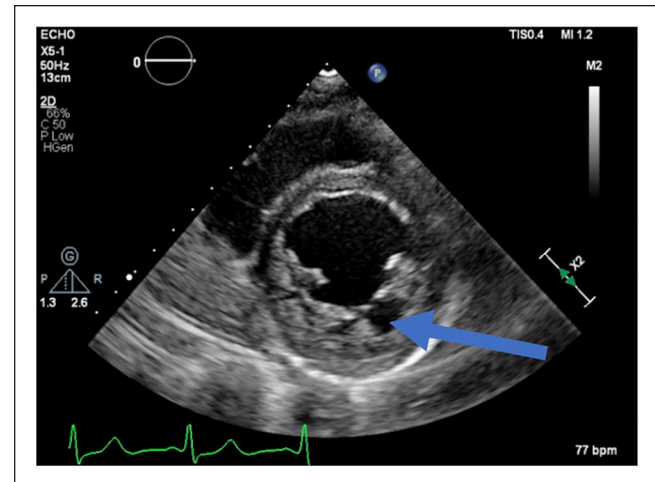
Echocardiogram, parasternal, short axis view showing left ventricular non-compaction (arrow).
